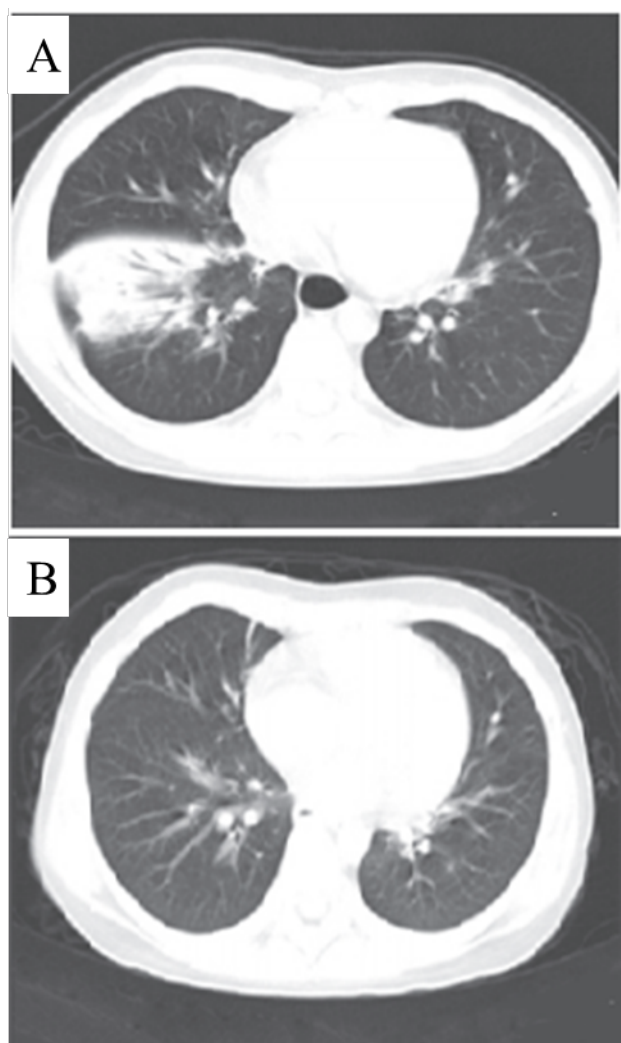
Chest X-ray before (A) and after (B) treatment
